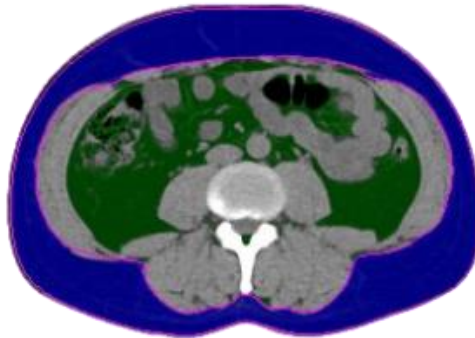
Cross-sectional axial image of the abdomen in which subcutaneous adipose tissue (blue) and visceral adipose tissue (green) may be distinguished. The image is obtained from a non-contrasted abdominal CT scan conducted for the CARBFUNC study at the Department of Heart Disease, Haukeland University Hospital.
